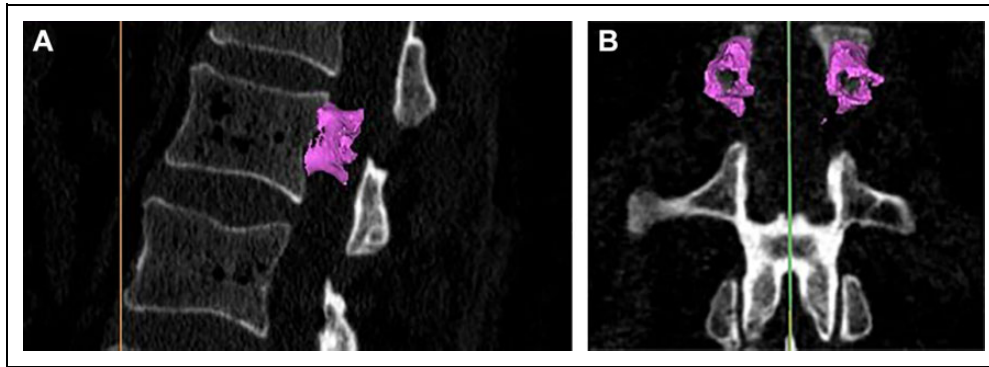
(A) Three-dimensional rendering of cortical bone within the pedicles of the L1 vertebra using (A) sagittal magnetic resonance images (MRI). Cortical and cancellous bone was separated by a filter algorithm provided by the segmentation software. (B) Three-dimensional rendering of cortical bone within the pedicles of the L1 vertebra using (B) coronal MRI. The methods used to determine cortical and cancellous bone mineral density (BMD) have been previously described in detail.^{26,28}
